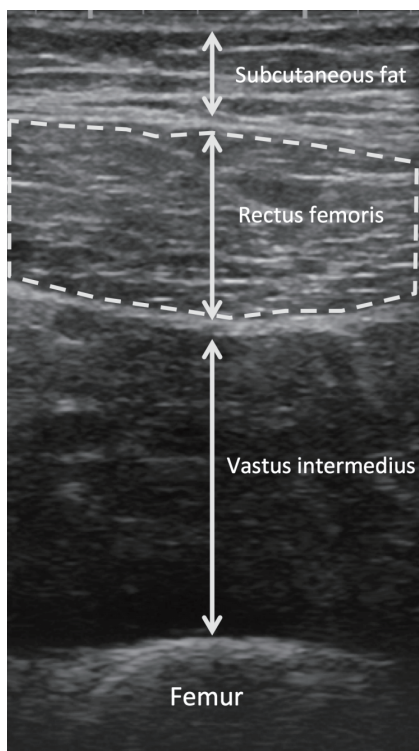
Transverse ultrasound image of the anterior part of thigh
